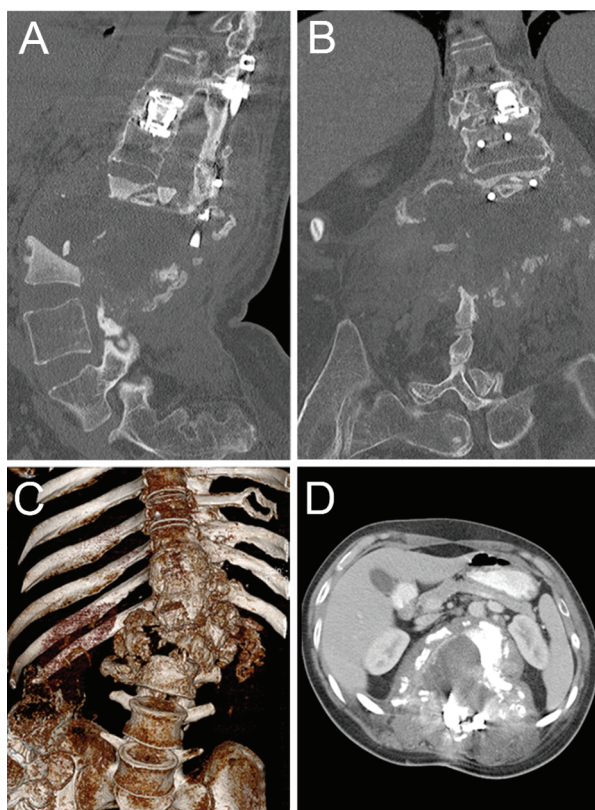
Images of the patient obtained 5 years after undergoing reconstruction and fusion. A–C: Sagittal (A), coronal (B), and 3D reconstructed (C) CT scans of the lumbar spine showing severe spinal breakdown with cyst formation below the previous fusion from T12–L3, consistent with Charcot disease of the spine. D: Abdominal CT scan demonstrating intraabdominal compression from the large degenerative retroperitoneal cyst.
